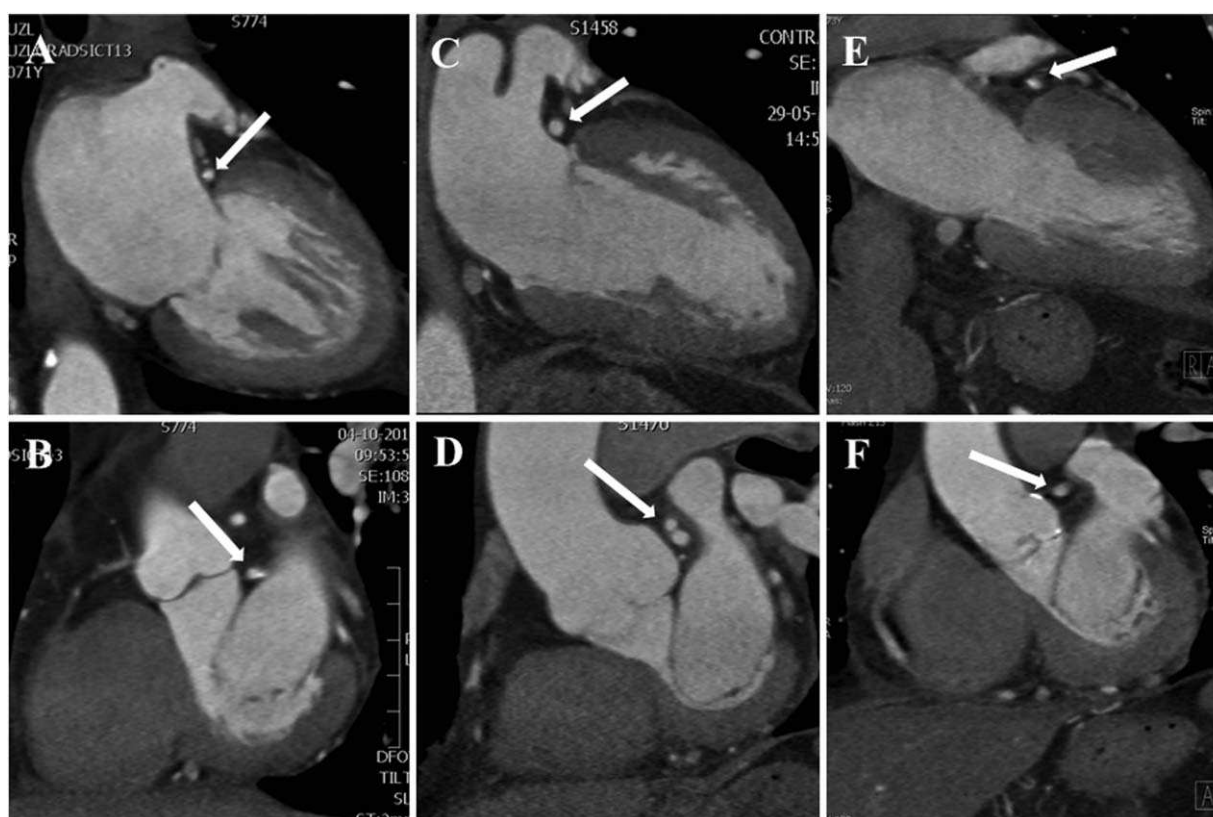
Long- and short-axis views of a coronary computed tomography scan in a patient with an anomalous LCx originating from the RCA with a retroaortic course (panels A and B) and a patient with a normal left dominant coronary circulation (panels C and D) showing the close relation of the LCx and the anterior mitral valve commissure (arrow). Long- and short-axis views in a right dominant circulation (panels E and F) demonstrate that the course of the LCx (arrow) runs at a greater distance from the mitral valve annulus.
